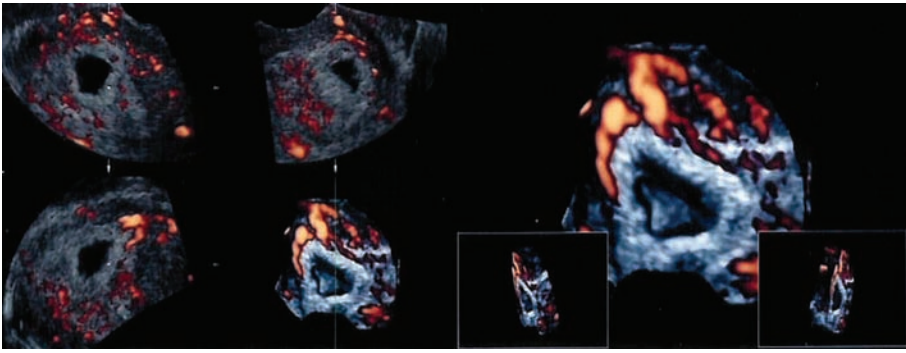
4D color Doppler of a normal gestational sac vascularization. Observe the trophoblastic rim.
